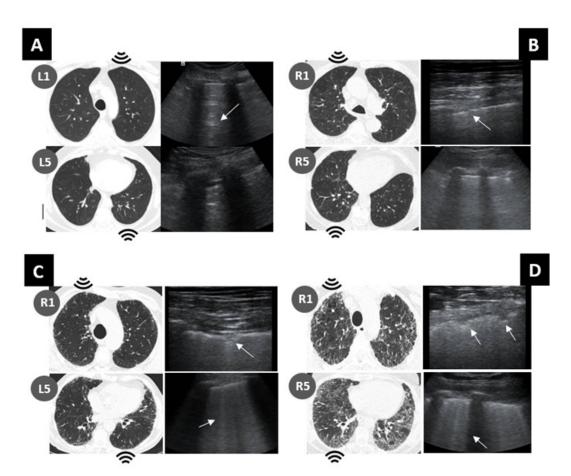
Correlation between sonographic and tomographic images. A) 52-year-old male patient with asthma, no pleural line changes, presence of multiple A lines, in relation with hyperinflation; B) 87-year-old male patient with non-fibrotic HP. R1: Ground glass and mosaic attenuation pattern on HRCT, correlating with pleural line discontinuity on ultrasound (US); R5: no HRCT or pleural line changes on US. C) 86-year-old male patient with IPF. R1: reticulation pattern on HRCT, correlating with pleural line irregularity on US; L5: reticulation pattern on HRCT, producing B-lines on US. D) 61-year-old female patient with fibrotic desquamative interstitial pneumonia. R1: honeycombing pattern on HRCT, irregularity and discontinuity; R5: honeycombing pattern on HRCT, creating abundant B-lines, commonly present in the interstitial syndrome.
